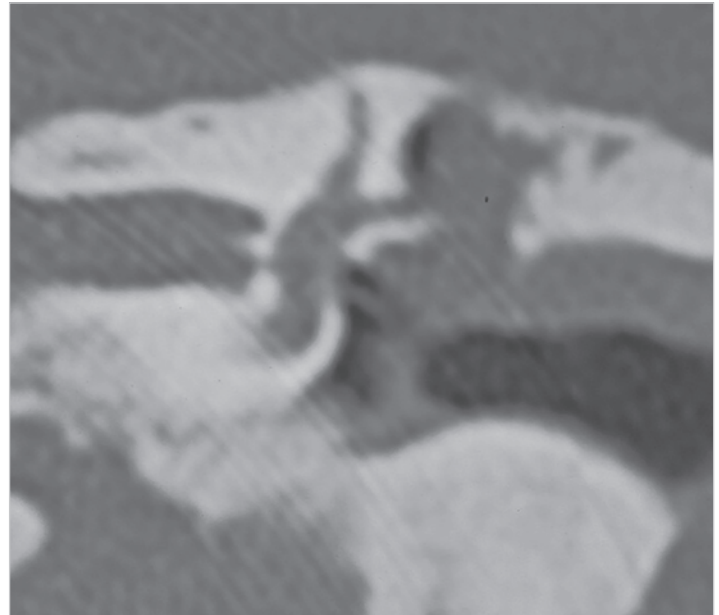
CT scan, coronal view, of the same case. The CT scan, performed 3 months before surgery, showed middle ear pathology compatible with cholesteatoma and suspected fistula of the lateral semicircular canal. The ear was discharging and the patient referred vertigo, while inner ear function was preserved.
